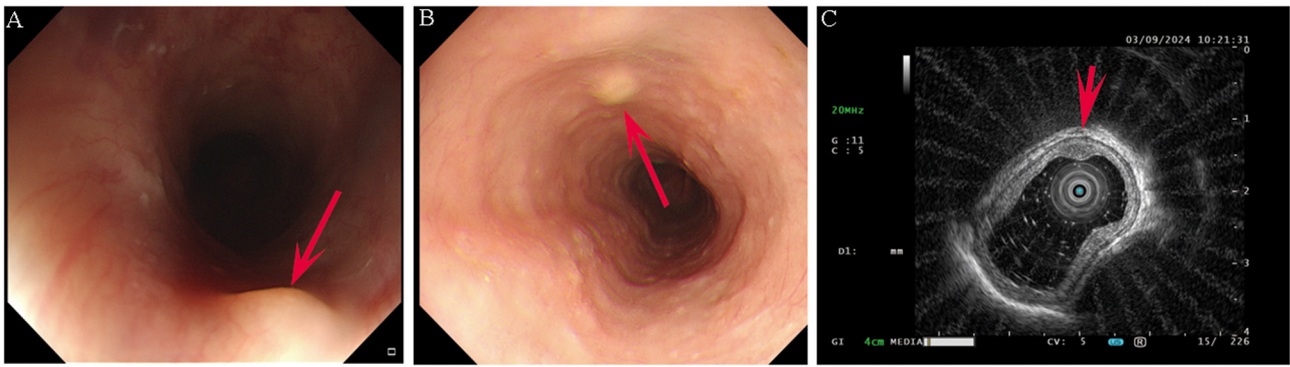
Ultrasound gastroscopy examination. (A and B) Gastroscopy showing submucosal protrusions in the esophagus, indicated by the red arrow. (C) Endoscopic ultrasound examination showing a submucosal protrusion in the lower oesophagus, marked by the red arrow.
